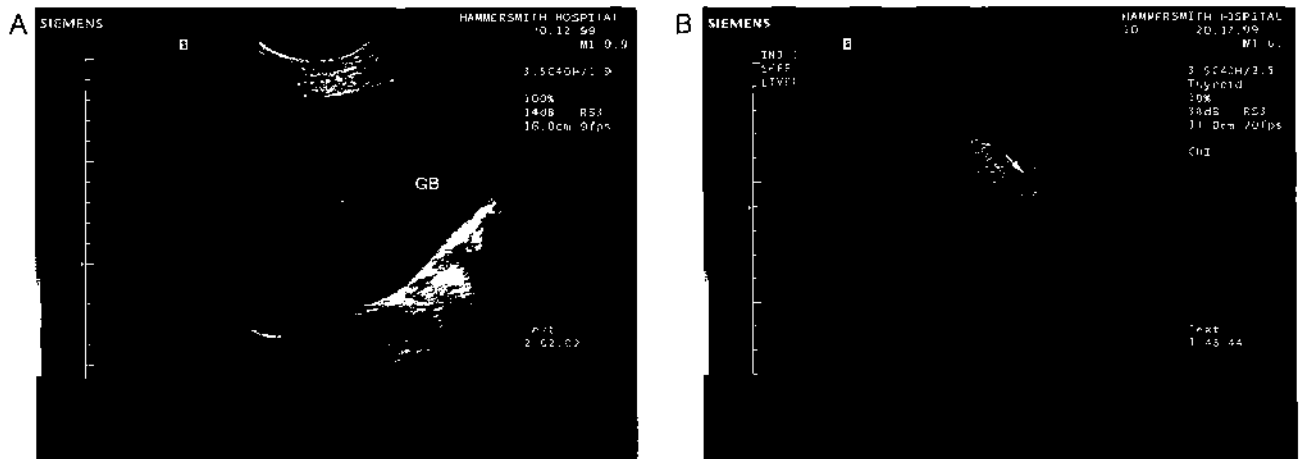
Occult hepatocellular carcinoma—contrast study. In this patient with cirrhosis, followup scans were performed to monitor the development of hepatocellular carcinoma. Only minor irregularity of the liver's texture was seen on the scan (A). He was entered into a phase 3 study of a new contrast agent, Sonazoid (Amersham, UK), and in the liver-specific phase a clear-cut lesion was revealed (arrow in B). Though the α -fetoprotein level was normal, an enhanced MRI study was performed and was read as normal. Three months later, the lesion became visible on unenhanced ultrasound and was confirmed on MRI and by biopsy to be hepatocellular carcinoma. Radiofrequency ablation was performed. GB, gallbladder.
